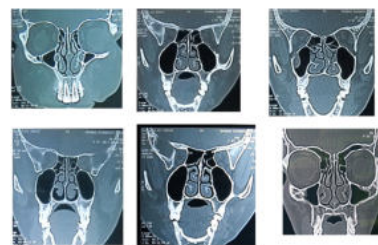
CT Scan of Paranasal Sinuses
